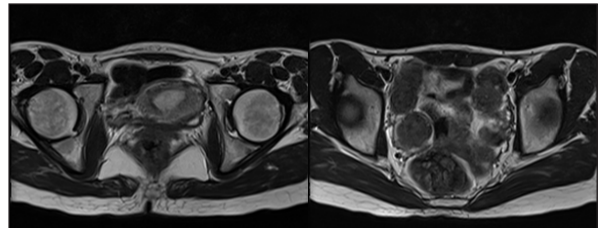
T2axial MRI sequences showing iso to hyperintense well defined lesion in right adnexa.
